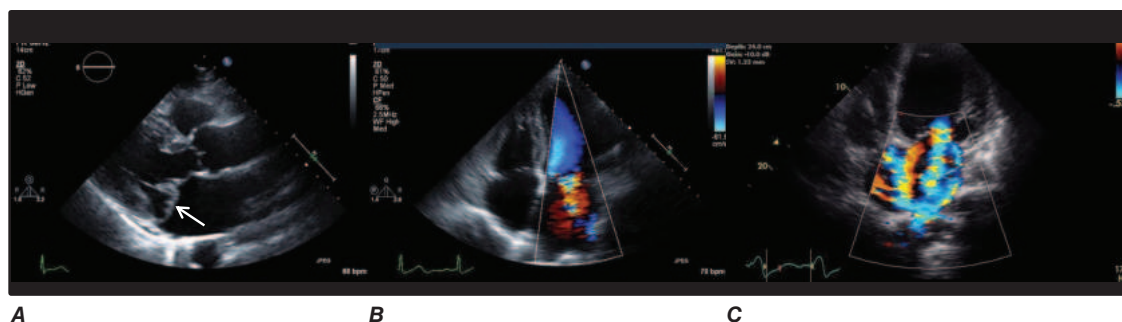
A. Mitral valve prolapse with posterior leaflet visualized prolapsing behind the plane of the anterior leaflet (arrow). B. Color flow Doppler showing mitral regurgitation in a patient with mitral valve prolapse. C. Severe functional mitral regurgitation in a patient with a dilated left ventricle.
